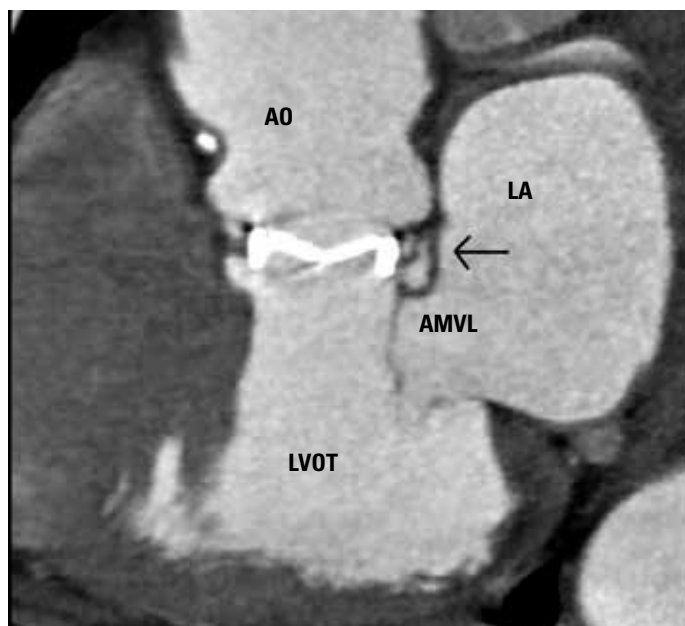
Multislice computed tomography image of a pseudoaneurysm in the mitral-aortic intervalvular fibrosa (arrow)
